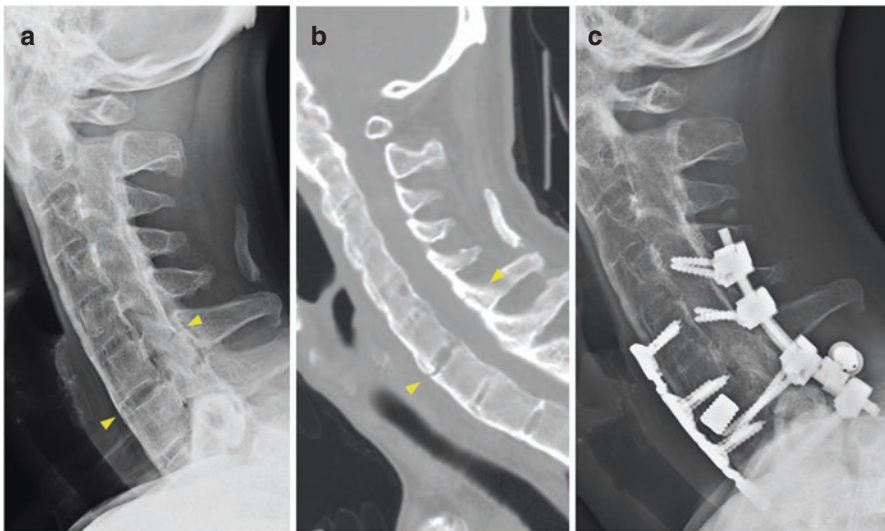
A 54-year-old AS patient with a falling accident and severe neck pain. (a) Plain lateral film showed a subtle fracture over C6-C7 (arrow heads), which can be easily missed. (b) CT showed a three-column fracture from the C6-C7 intervertebral disc space to the C6 posterior column (arrow heads). (c) Plain lateral film after C6-C7 ACDF and C4-T1 posterior fixation. A long construct is often necessary for cervical fractures among AS patients
